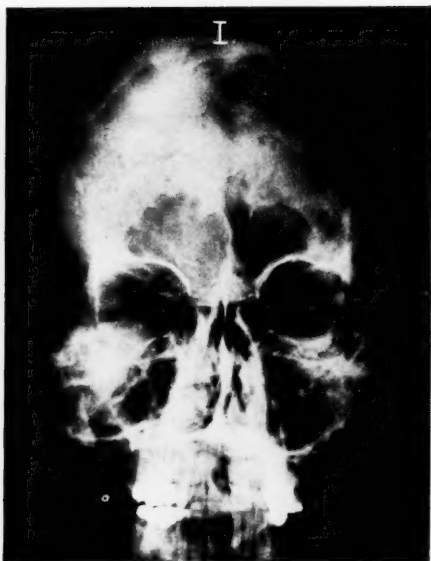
X-ray films of Case 10. Film I was taken on March 2, 1942. Note the cloudiness of the right frontal sinus and the sclerotic bone at the boundaries of the sinus.
